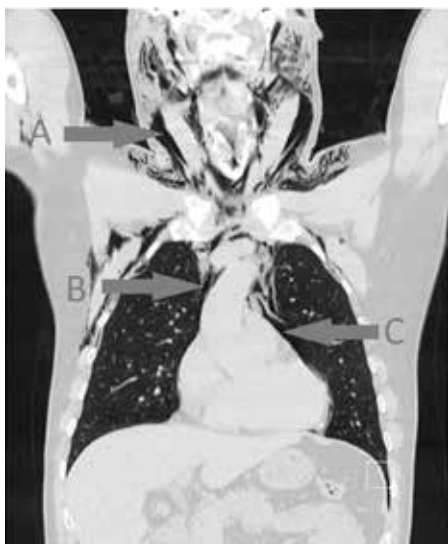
Coronal CT showing air in the neck (A) and mediastinum (B, C).
